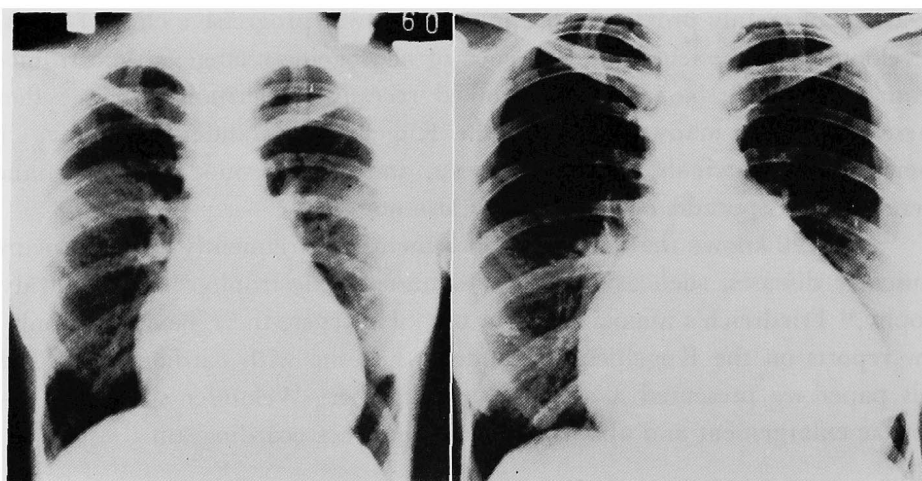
Chest X-ray film on admission (right, October, 1978) showing marked cardiomegaly compared to the one taken about 1 year previously (left, July, 1977).
